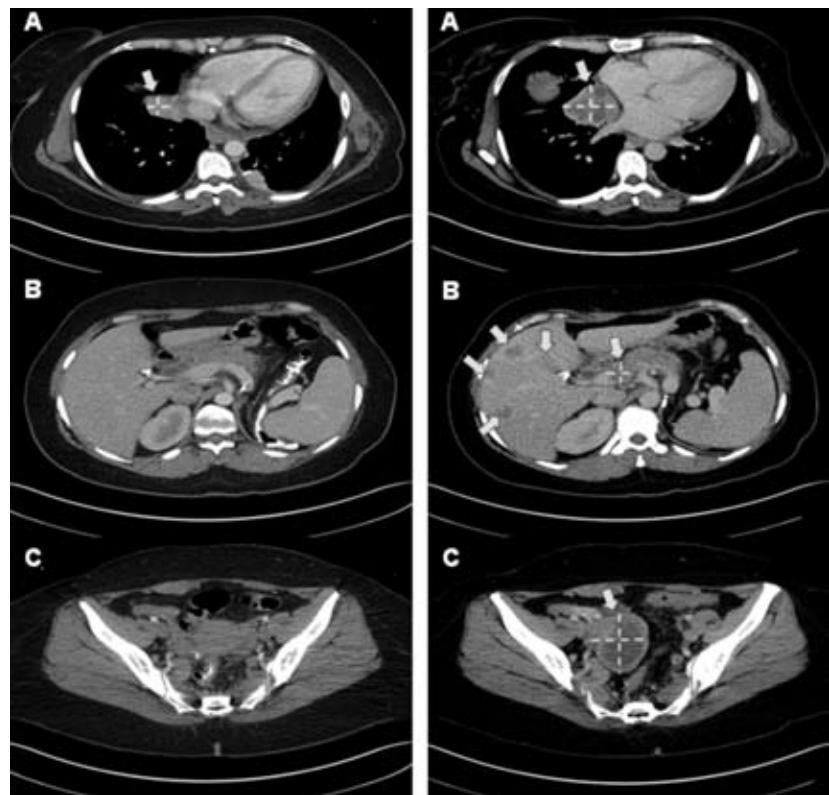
Computed tomography scan of abdomen and pelvis showing diffuse metastases involving the liver (B), pancreas (B) as well as a cardiophrenic mass (A) and right ovarian mass (C).
